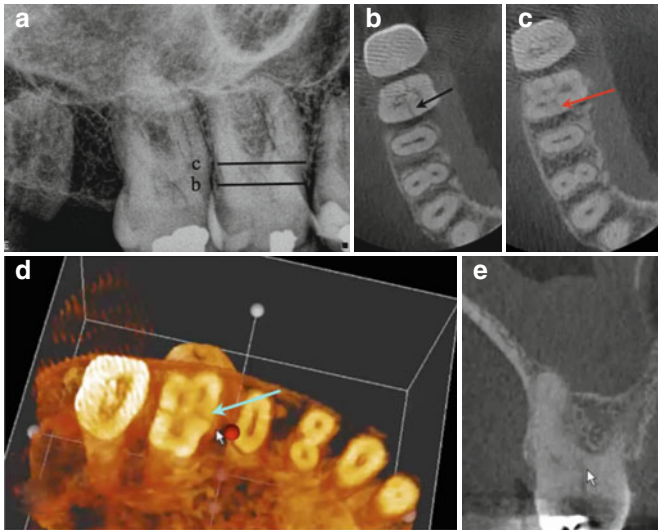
(a) Periapical radiograph of tooth number 3. The patient presented complaining of pain to cold and biting. Periodontal probing depths were WNL. Lines correspond to the axial sections in (b) and (c). (b) and (c) are axial views showing the extent of the fracture (black and red arrows in (b) and (c), respectively). (d) 3D reconstruction, axial view of (c) showing the mesial-distal crack (blue arrow). (e) A coronal view demonstrating extension of the fracture into the furcation
